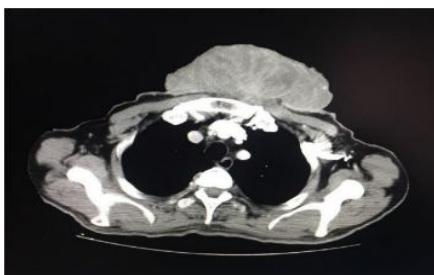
CT Scan of the Chest with Exophytic Lesion in the Anterior Thoracic Wall.
